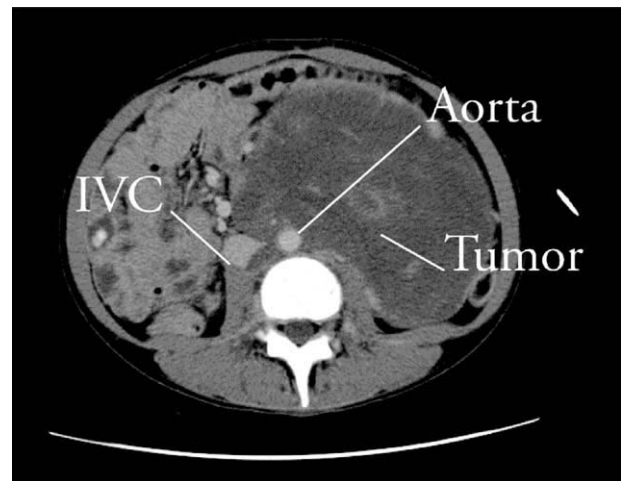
Preoperative computed tomographic scan showing a large neuroblastoma encasing both the distal aorta and inferior vena cava, just above the level of aortic bifurcation. IVC indicates inferior vena cava.
